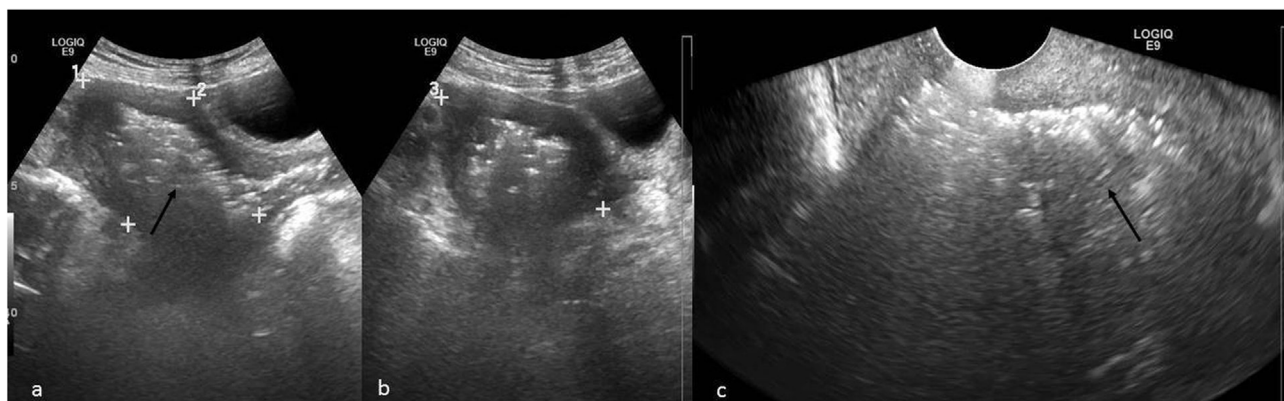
Trans abdominal (a,b) and trans vaginal (c) ultrasound images showing distended endometrial cavity with multiple echogenic foci within its lumen with dirty posterior shadowing suggestive of air locules within (black arrows).
